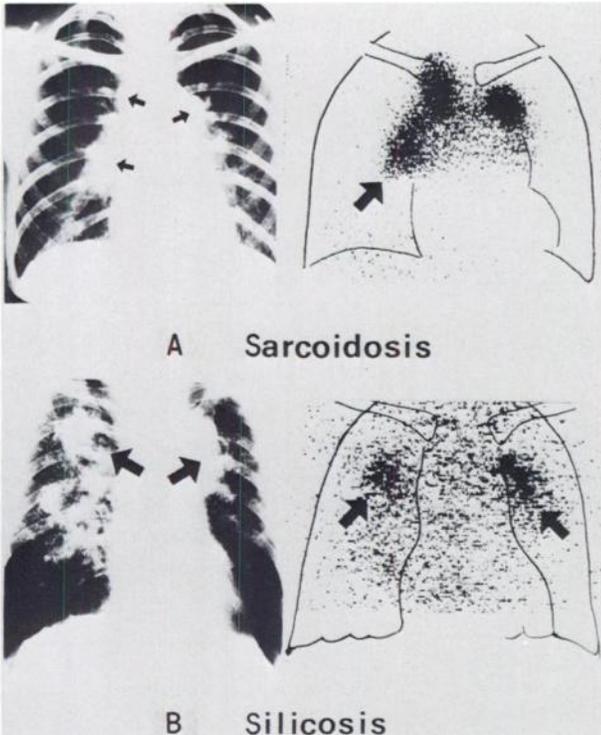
Case 5, sarcoidosis, and Case 6, silicosis. Chest x-ray (A) of sarcoidosis shows enlargement of hilar regions bilaterally. Gallium-67 scintigram reveals strongly positive scan corresponding to shadows on chest x-ray. Chest x-ray (B) of silicosis shows proliferative and nodular shadow in upper lung fields bilaterally. Gallium-67 scintigram reveals positive scan corresponding to shadow on chest x-ray.
